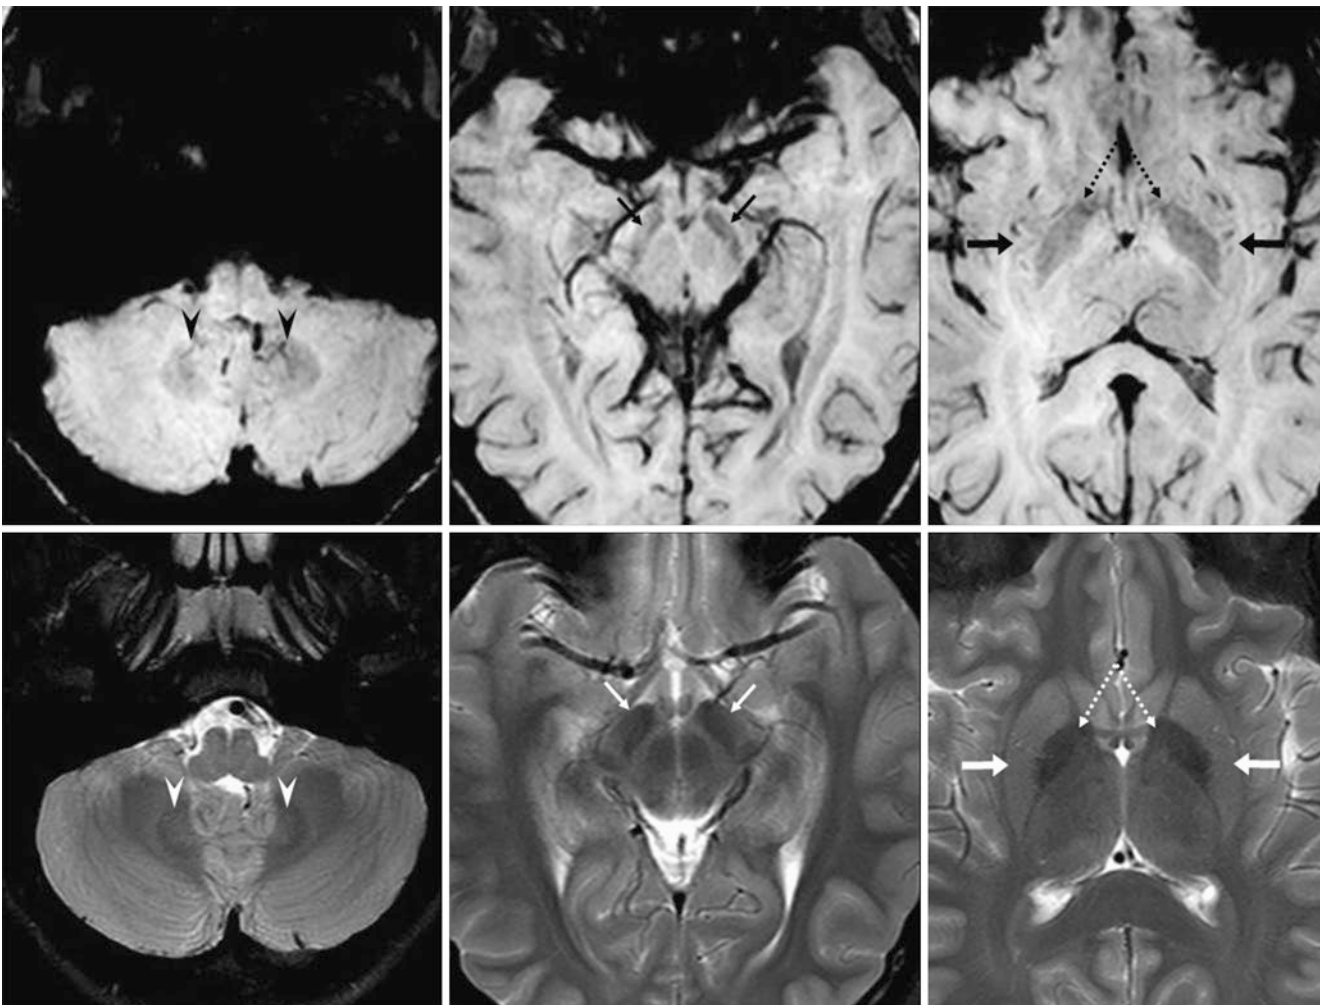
A 15 year old with a normal 3T MRI for headaches. There is mild, early iron deposition within the dentate nuclei (*arrowheads*), SN (*thin arrows*), and GP (*dotted arrows*) on axial SWIs (*top row*). The
